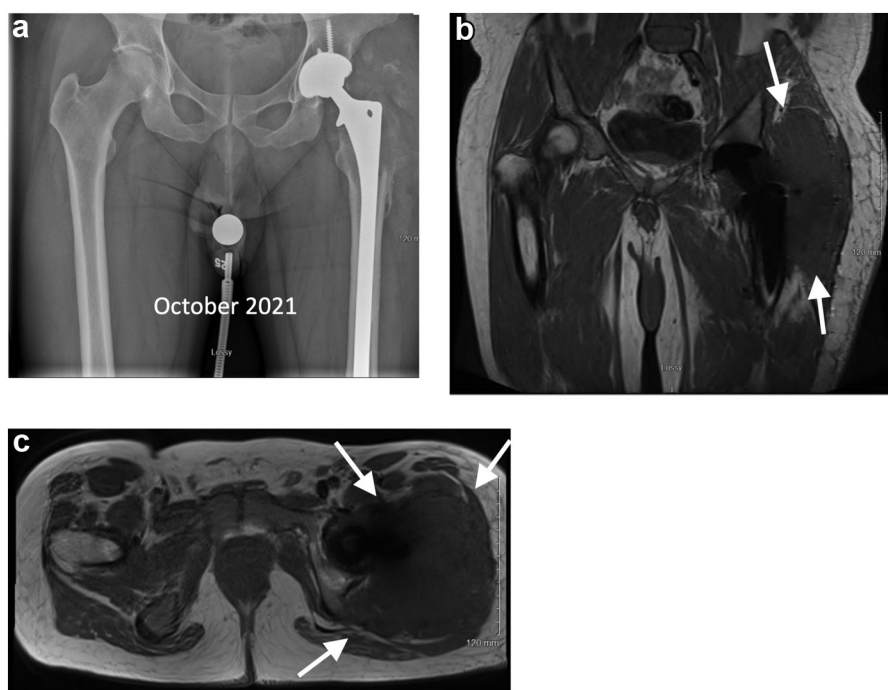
(a) Anteroposterior radiograph of pelvis and left hip showing extensive lytic erosion involving the left greater trochanter and proximal diaphysis. (b) Coronal and (c) axial views of MARS MRI showing marked interval size increase of the left periprosthetic mass to $12 \times 11 \times 16$ cm. There is circumferential involvement of the medullary cavity of the left proximal femur with associated posterolateral cortical disruption. There is extension to the left gluteal, ischiofemoral, and anterior-proximal thigh compartments, as depicted by the arrows (October 2021).
